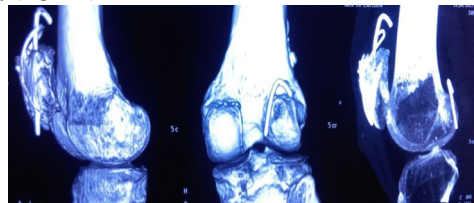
CT scan showing location of migrated wire before the surgery
